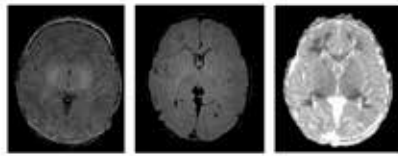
Day 10. From left to right: cerebral MRI in T1, FLAIR, and diffusion-weighted image. The first image shows hyperintense lesions in the white matter, especially in the frontal and the parietal regions. The frontal white matter shows signs of necrosis. Diffusion-restricted lesions are found in the corpus callosum.
